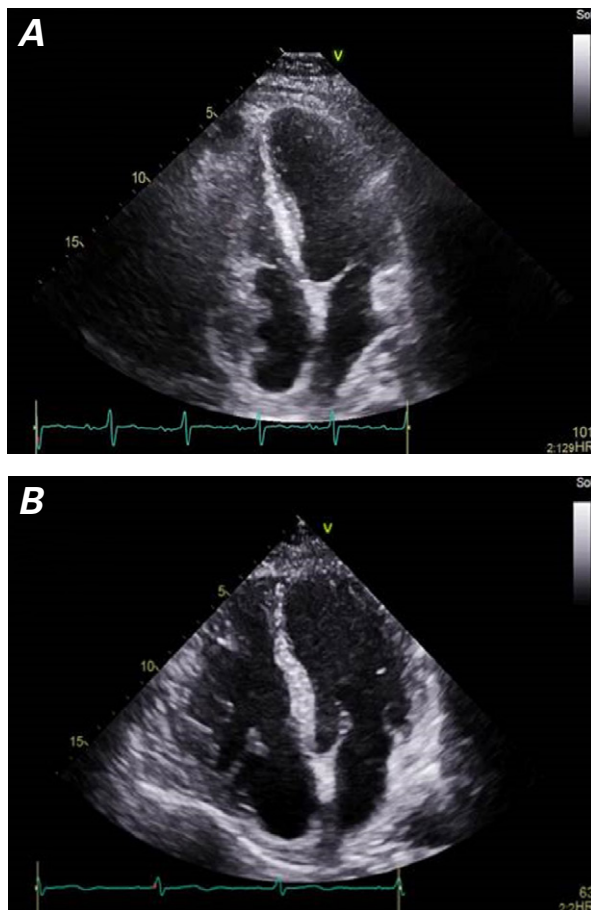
Transthoracic echocardiograms. A) Twelve days after chemotherapy began, the mass was substantially smaller; B) 18 months later, it had almost disappeared.
